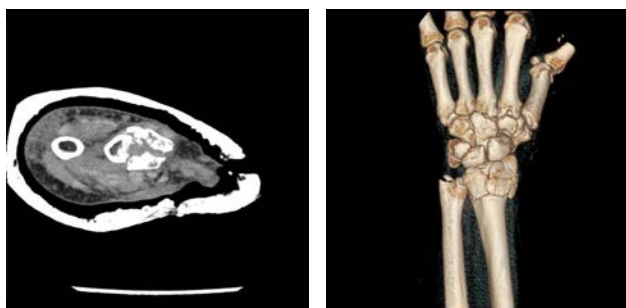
CT-scan, 42 yo female. Intra-articular radius fracture AO Type 23-C3 with minimal displaced fracture of the ulna styloid
